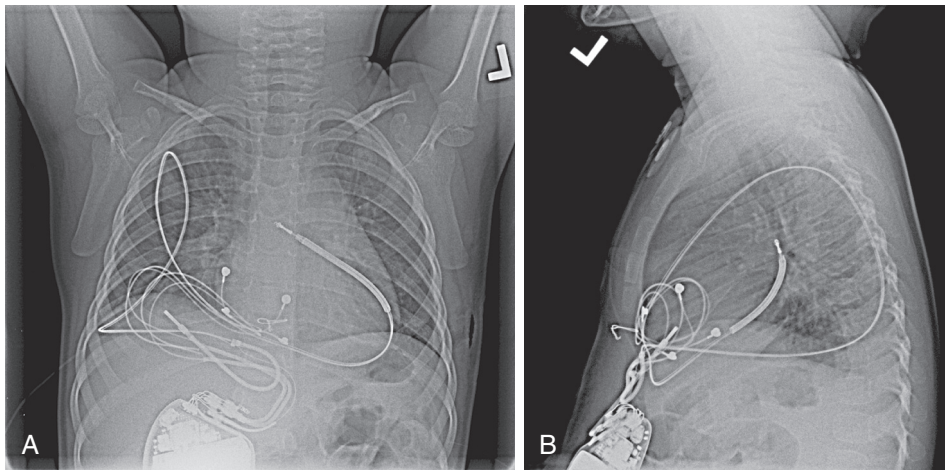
■ Chest radiographs of an infant who underwent a minimally invasive nontransvenous cardioverter-defibrillator implantation. A, Anteroposterior view. B, Lateral view. Note the use of a standard transvenous lead in the pericardial cavity.
